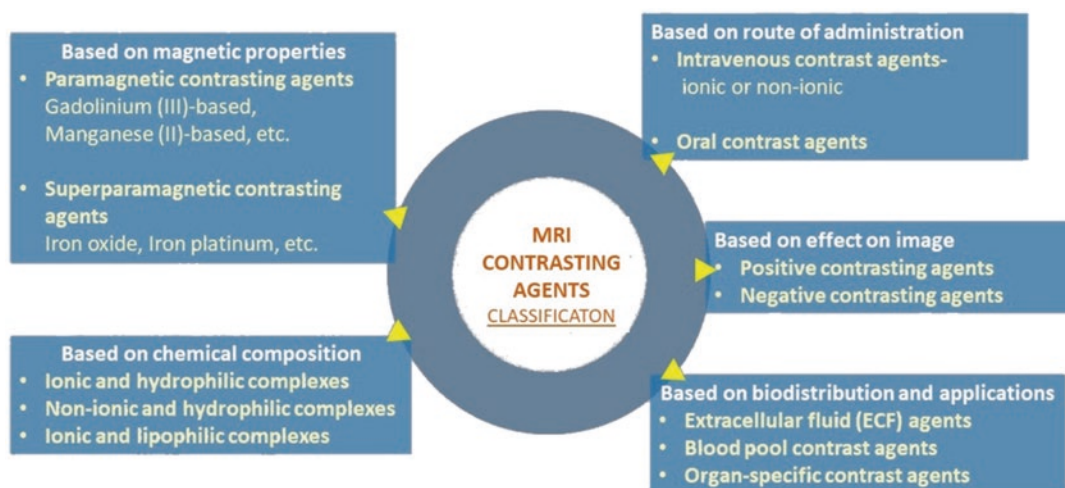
MRI contrasting agents classified on the basis of magnetic properties, chemical composition, route of administration, effect on image, and biodistribution and applications [37]
